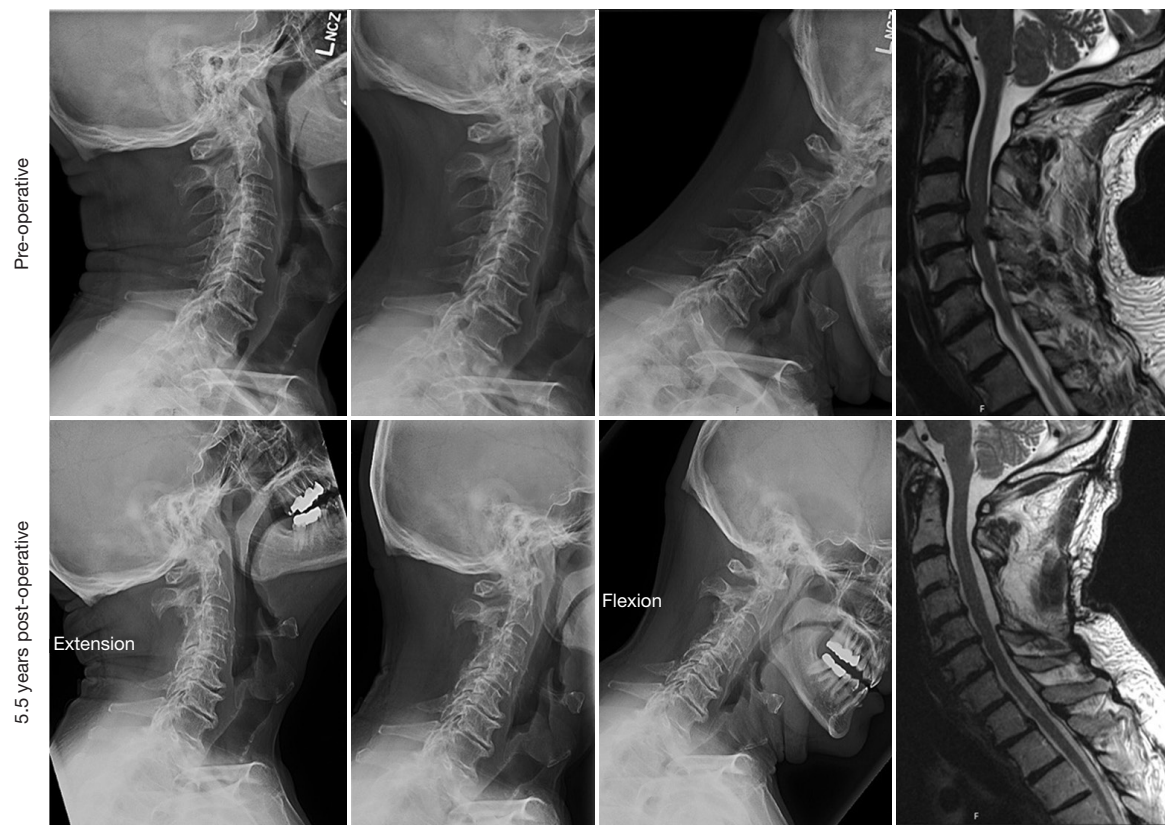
Flexion-extension X-rays and sagittal T2 MRI at pre-operative baseline and 5.5-year follow-up. This patient presented with cervical radiculopathy and myelopathy. Pre-operative MRI showed multilevel changes with cord deformation and compression at C3–4 and C4–5. Flexion extension films showed preserved cervical lordosis with no evidence of pathologic motion. Repeat imaging was obtained 5.5 years post operatively which shows mild loss of lordosis, but no abnormal motion. MRI shows excellent decompression without development of stenosis at the adjacent levels. MRI, magnetic resonance imaging.
